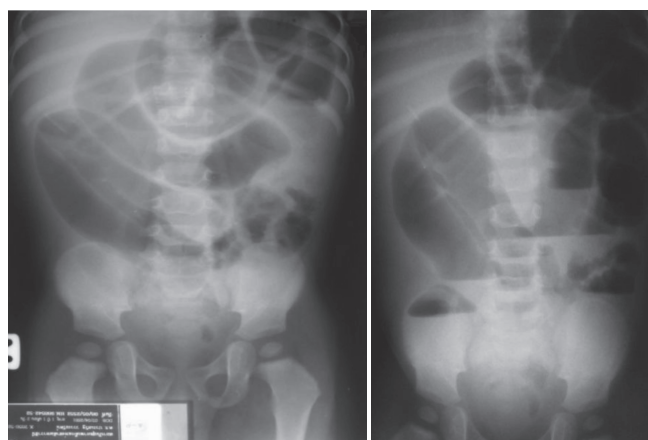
Complete intestinal obstruction from plain films of abdomen
